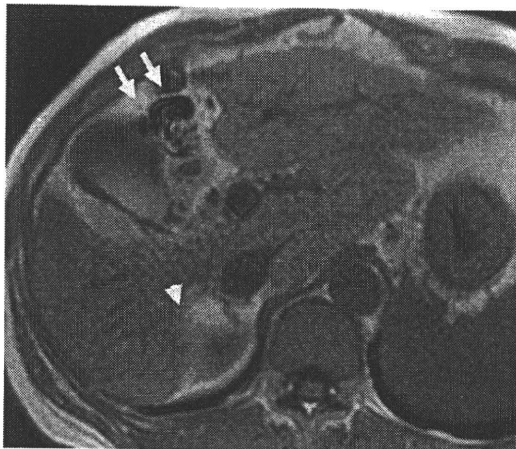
T1-weighted gradient-echo (GRE) in-phase (TE, 4.7 ms) image in advanced cirrhosis shows enlargement of the pericholecystic space, presenting the expanded gallbladder fossa sign (arrows), and sharp indentation in the right medial posterior surface, presenting the right posterior hepatic notch sign (arrowhead).
